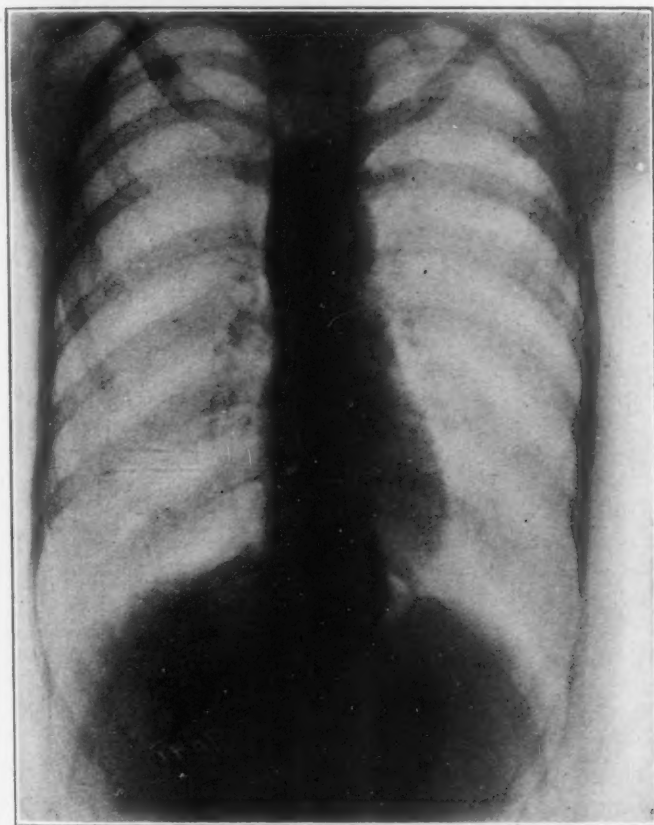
Radiograph (by Dr. J. C. Bowen) of a woman of 28 years showing an abdominal esophagismus with only very slight dilatation above it. The deviation of the esophagus by the aorta was verified esophagoscopically.
